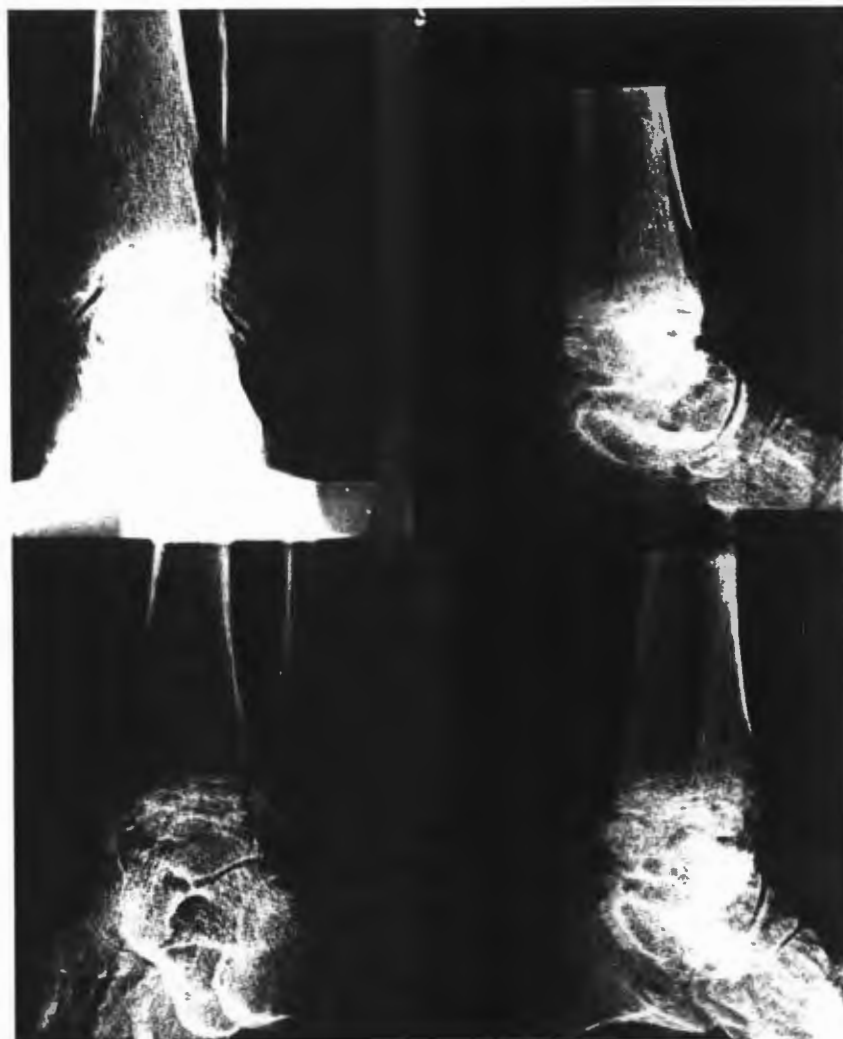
(c). FOA: Radiographs of the ankle of an affected female aged 56 years (III-18). The joint space is narrow and irregular with large osteophytes and considerable sclerosis.
